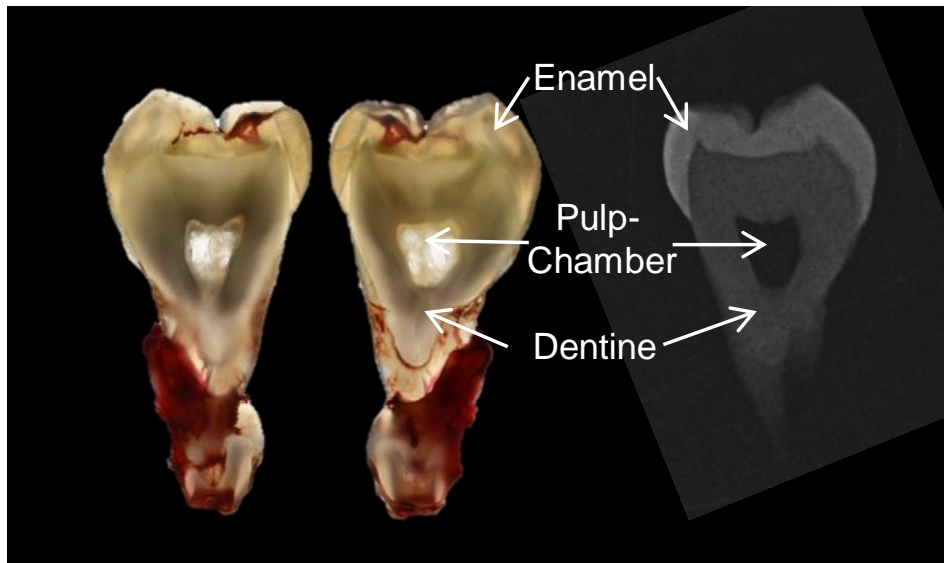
Tooth 1 tissue-slice 6, photographed both sides (front and back) and corresponding radiograph taken at 60kV 7mA 0.125s showing highly-mineralised enamel as light grey, less-mineralised dentine as darker grey and the location of the pulp-chamber as virtually black in the centre of the tooth.
